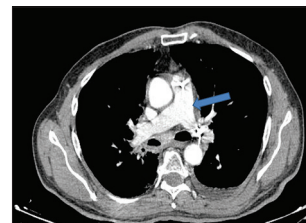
Computed tomography thorax done after 48 h of starting alteplase showing resolution of thrombus
